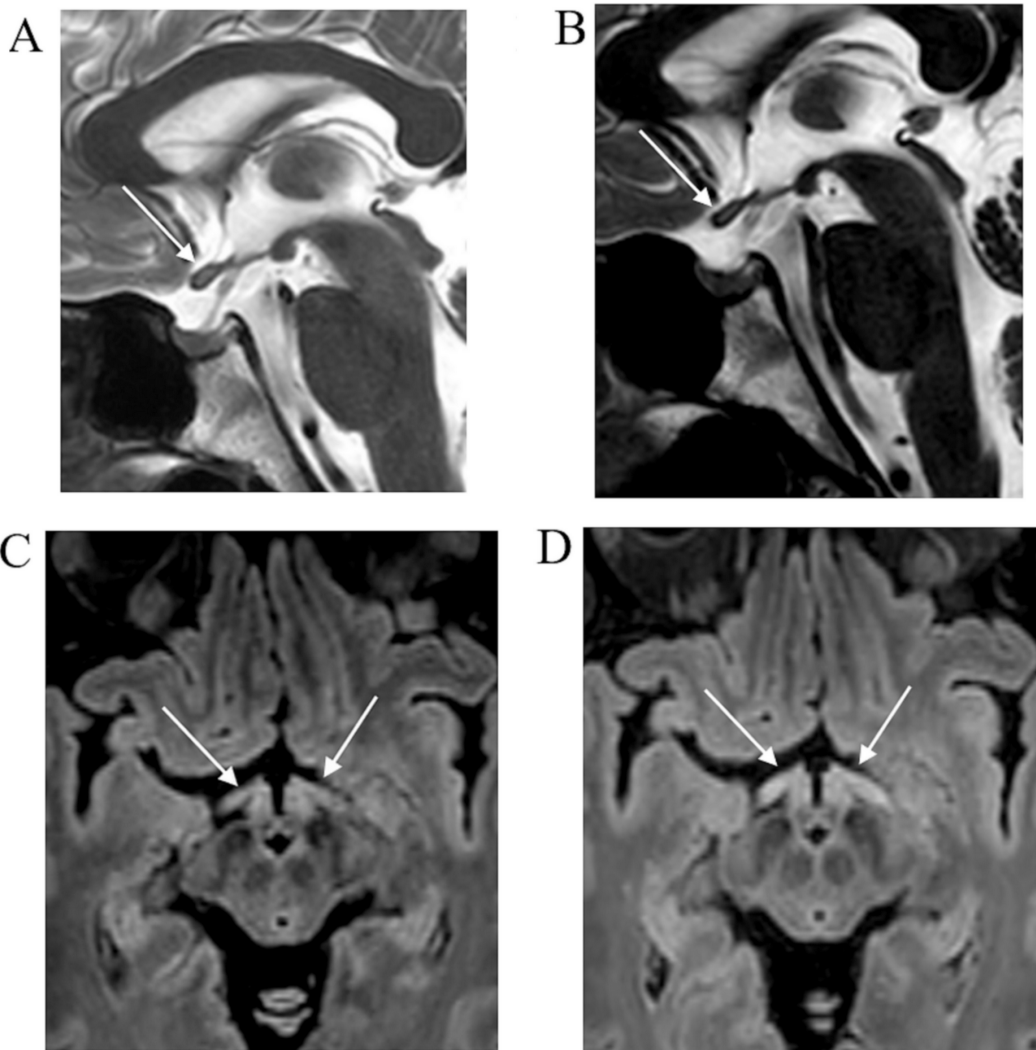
Series of MRI brain scans in March 2021 (A, C) and control in June 2021 (B, D). Sagittal T2 sequence (A) shows signal change centrally in the chiasma (arrows); in the check-up examination (B) signal change persists, chiasma atrophy occurs. FLAIR (C, D) shows the evolution of signal changes over time (arrows), with the progression of changes on the MRI follow-up scan in June (D).
